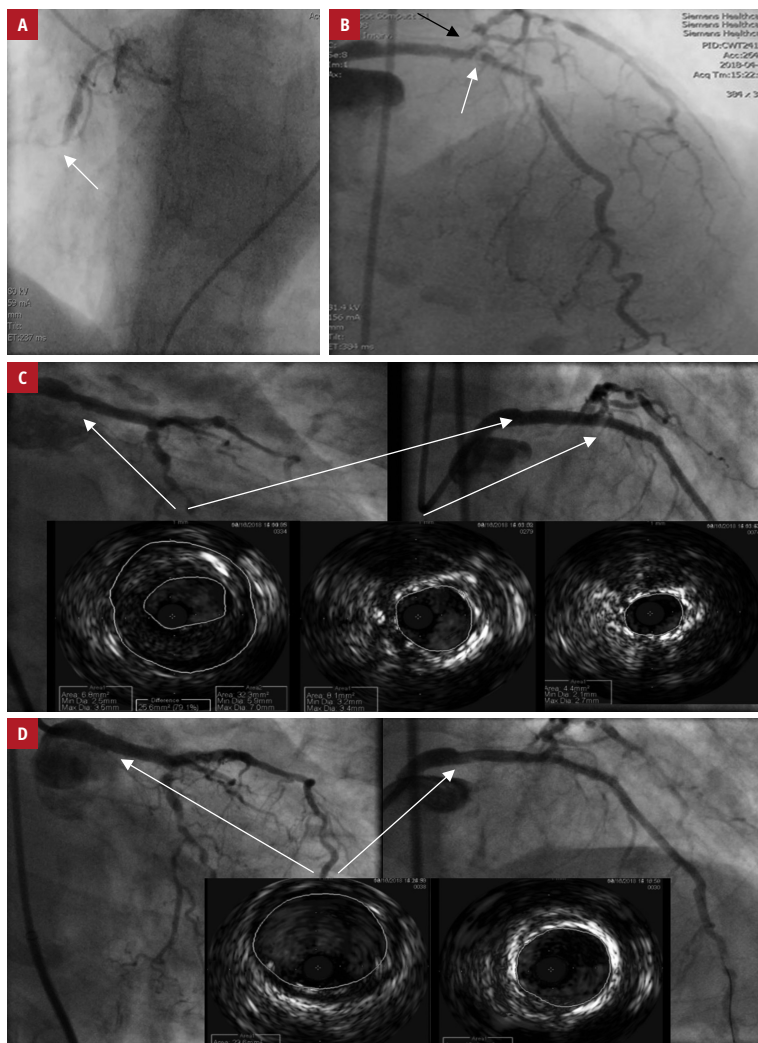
A – right coronary artery occluded in the medial segment (arrow); B – heavy calcifications, 99% stenoses in the left main coronary artery (LMCA) and the ostium of the left anterior descending artery (LAD) (white arrow), 90% narrowing in the medial and distal LAD, 99% stenoses in the proximal and medial circumflex artery (black arrow); C – significant stenosis of the LMCA (arrows) imaged in intravenous ultrasound (IVUS); D – IVUS of LMCA after stent implantation
